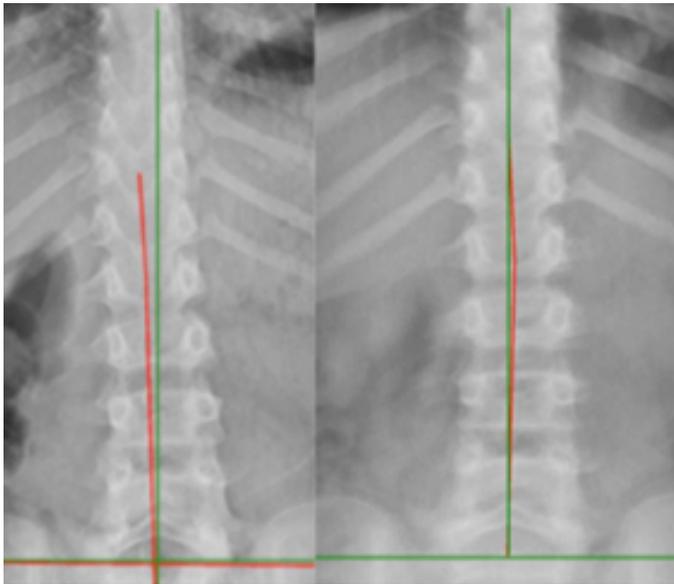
Anteroposterior lumbar radiographs. Left: Pre shows a pseudo-scoliosis/right lateral thoracic translation of 6.6mm. Right: Post shows reduction to 0mm. Note: Red line indicates patient; green line indicates vertical (CBP Seminars, Inc.).
